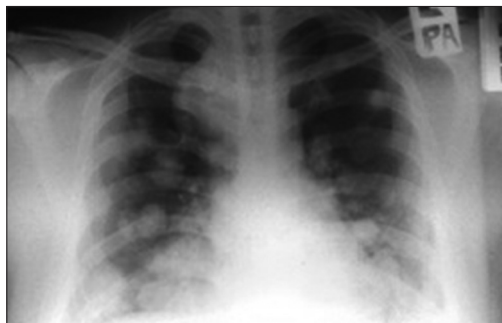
Chest x-ray (October 2011)
